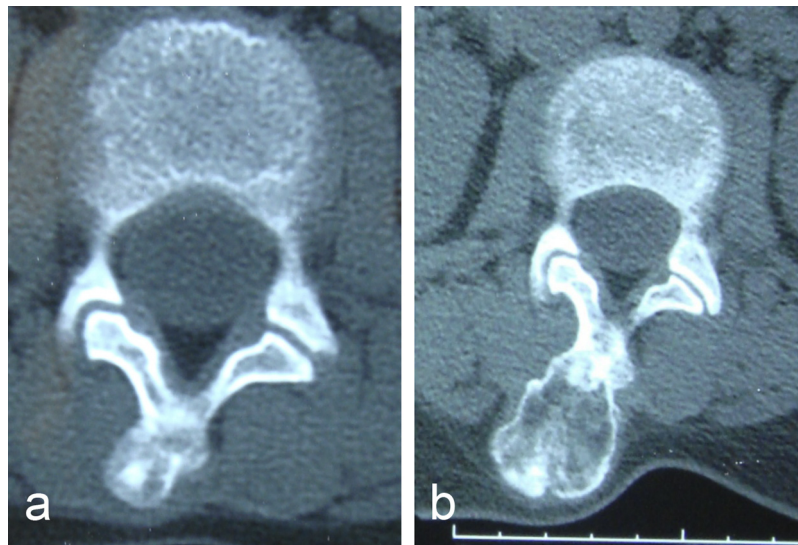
(a) Axial CT of the lumbar spine shows the L2 spinous process osteochondroma. (b) Follow up CT showing considerable enlargement of the tumour.
